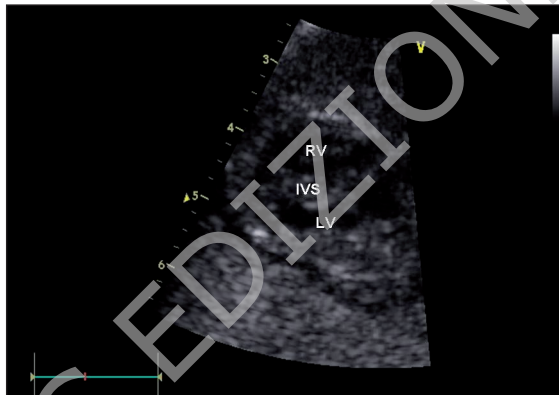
Fetal echocardiography showing hypertrophic cardiomyopathy.
